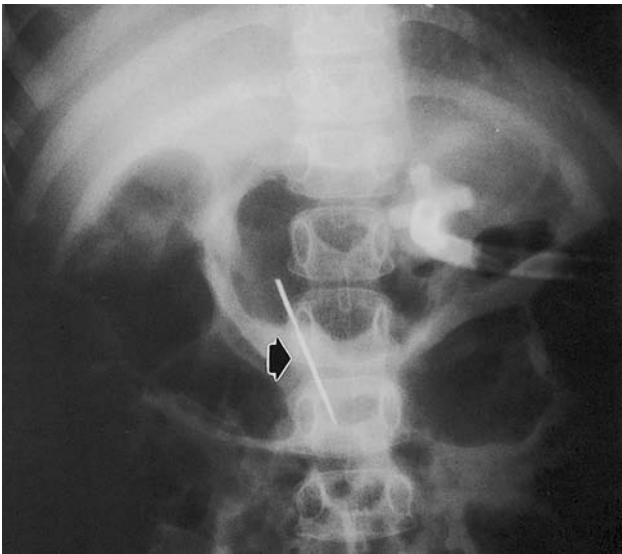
Gastric foreign body. This 6-year-old developmentally delayed patient ingested a large straight pin that caused bleeding of the gastric antrum. The *arrow* represents the foreign body. An opaque gastrostomy tube is also radiographically present.
